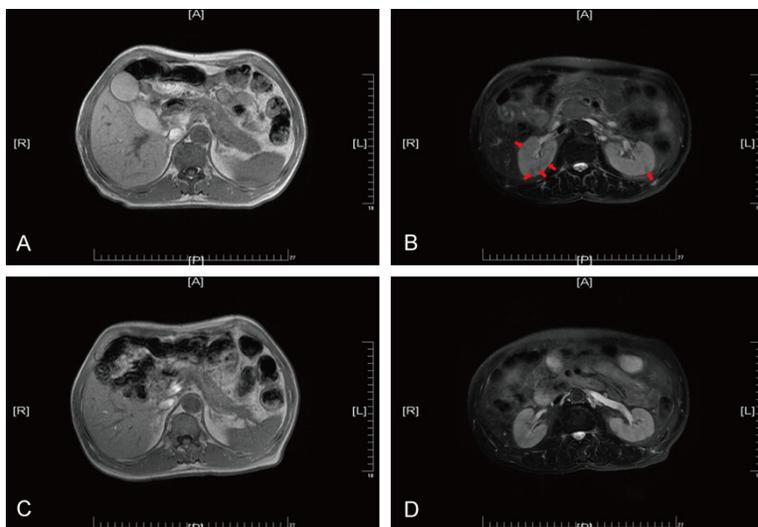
MRI of the abdomen (A and C were T1 MRI) (B and D were T2-fs MRI). (A) The pancreas was diffusely thickened and enlarged, with a blunt appearance like sausage; the common bile duct, gallbladder, intrahepatic bile duct were all mild-to-moderate dilated. (B) The size and appearance of the bilateral kidneys were both normal, but a multiple patchy reduced signal intensity area was observed in the renal parenchyma (red arrows). (C) The pancreas was mildly enlarged, but the pancreatic duct, common bile duct, gallbladder, and intrahepatic bile duct showed no obvious dilatation. (D) The size and appearance of bilateral kidney both showed no apparently abnormal signs.
